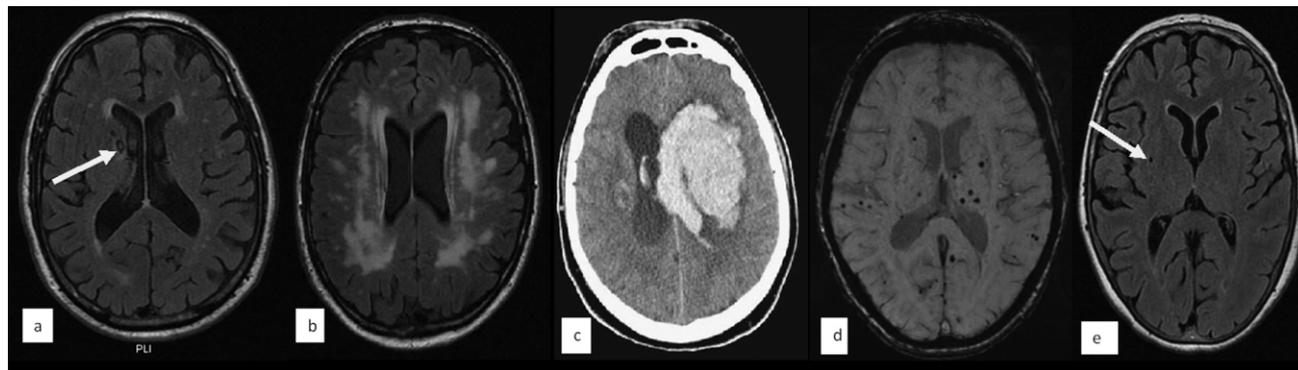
Radiological phenotypes of cerebral small vessel disease (images a,b,d & e from the Tasmanian Cognition and Gait Study). (a) Deep brain infarcts (arrows) on fluid attenuated inversion recovery (FLAIR). (b) Severe white matter lesion. (c) Large intracerebral haemorrhage with smaller right-sided haemorrhage. (d) Cerebral microbleeds (arrow) on susceptibility-weighted image imaging. (e) Enlarged perivascular space (arrow) on FLAIR.
